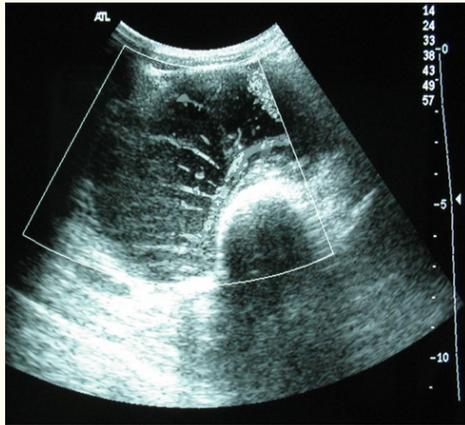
Abdominal Doppler ultrasound: hypervascularized retroperitoneal mass.
